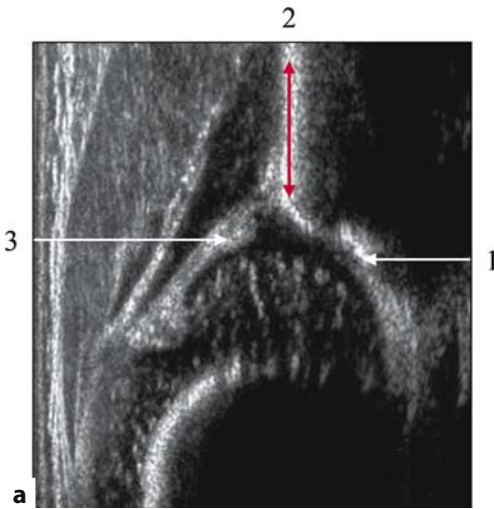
a Checklist points of the anatomical identification prior to reading a sonogram. *1*, Lower limb of the os ilium; *2*, standard sectional plane; *3*, acetabular labrum. Sonogram is acceptable for reading only if all three landmarks are present. b Image obtained with posterior tilting of the probe: The lower iliac limb is clearly visible; however, the sectional plane is posterior. This sonogram cannot be used for diagnostic interpretation. c A sonogram performed through a posterior sectional plane: The lower limb of the iliac bone and the labrum are not visible. This sonogram cannot be used for diagnostic interpretation
